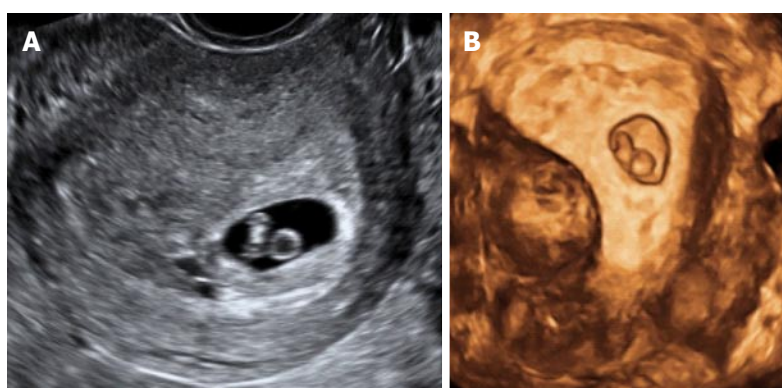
Intramural fibroid with an intrauterine pregnancy. A: Transverse 2D ultrasound image showing an intrauterine gestation sac positioned towards the left endometrial cavity; B: 3D coronal ultrasound image showing an intramural fibroid distorting the endometrial cavity, thus deviating the intrauterine pregnancy towards the left endometrial cavity. 3D: Three-dimensional; 2D: Two-dimensional.
